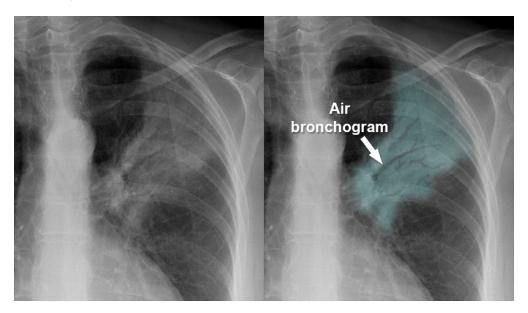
Air bronchogram in lung consolidation X-ray detail
